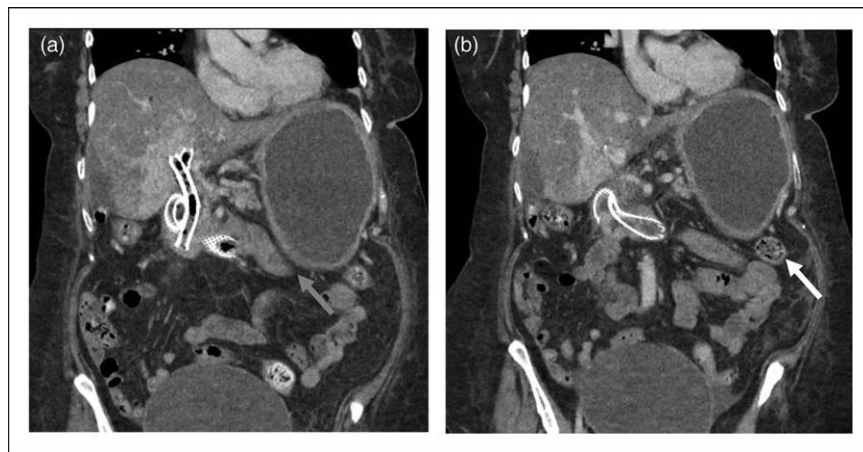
A patient with two prior failed duodenal stents presents with recurrent gastric outlet obstruction. (a) Coronal view of CT scan showing proximity of the proximal jejunum (grey arrow) to the gastric wall, (b) but also note the proximity of the transverse colon (white arrow).
